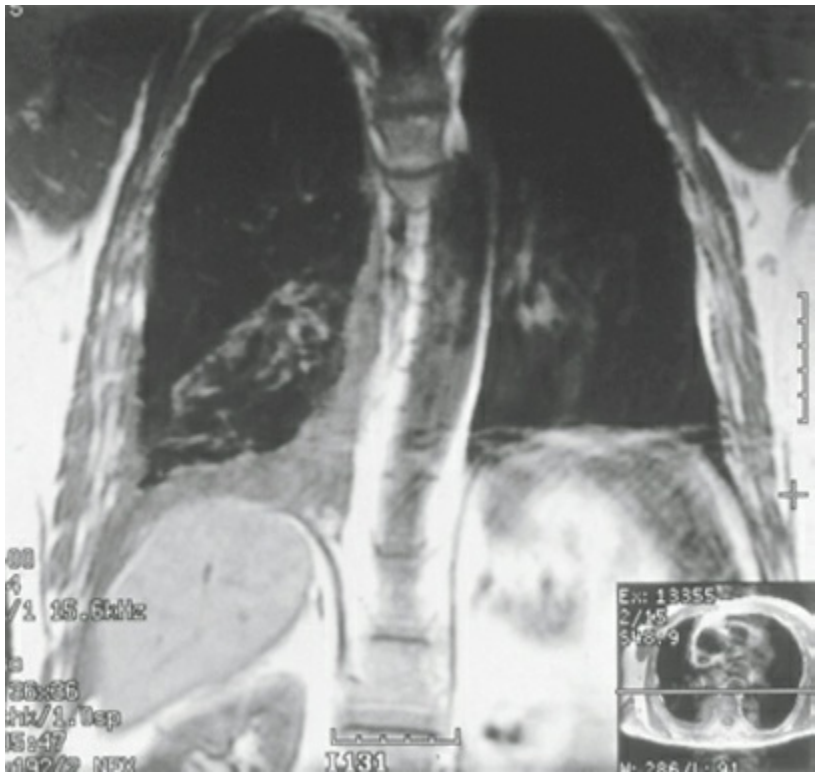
Magnetic resonance imaging of the patient in Figure 80-25 shows a large amount of tumor within the pleural space and into the diaphragmatic sulcus with no evidence of extension outside the hemithorax. (Reproduced with permission from Flores RM, Sugarbaker DJ. Malignant mesothelioma of the pleural space. *Ann Thorac Surg* 2000;70:306.)
